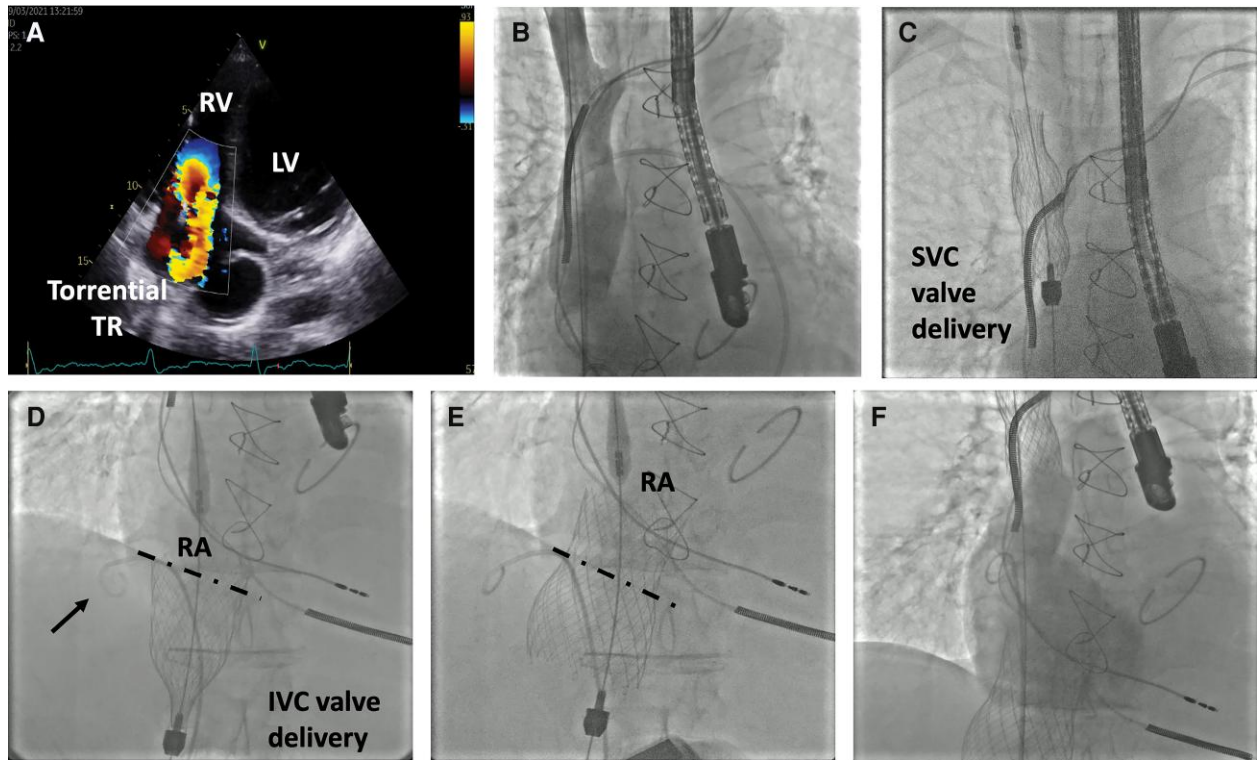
Initial echocardiogram and procedure of Patient 1. (A) Transthoracic echocardiogram (apical four-chamber view) showing torrential tricuspid regurgitation. (B) Initial venography with substantial iodine contrast reflux. (C) Superior vena cava valve deployment. (D, E) Consecutive images of inferior vena cava valve deployment, with a pigtail catheter in the supra-hepatic veins (arrow). Using the ICD lead as a landmark, it is possible to appreciate cranial device displacement after release. (F) Final venography showed no significant leak. TR, tricuspid regurgitation; RV, right ventricle; LV, left ventricle; SVC, superior vena cava; IVC, inferior vena cava; RA, right atrium.
